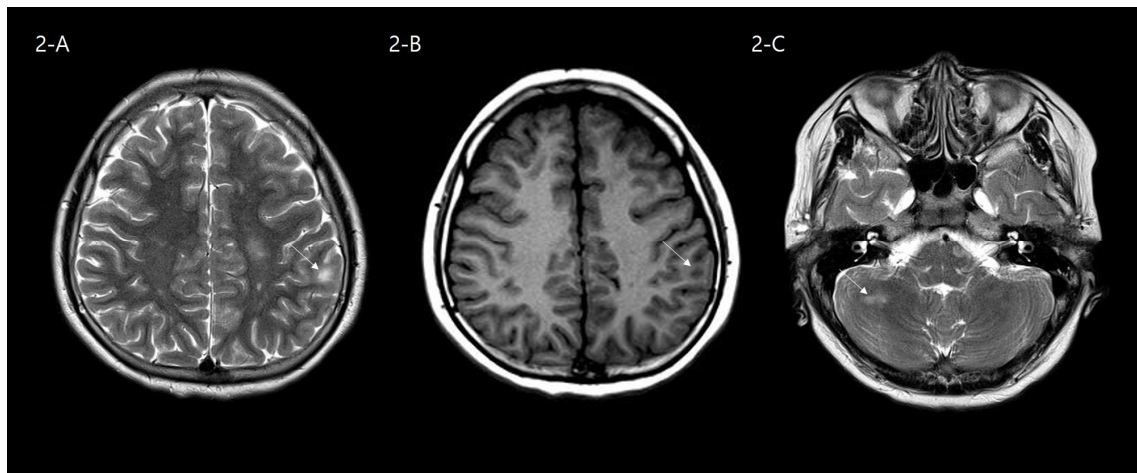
Brain MRI of patient 33 diagnosed with MS (oligoclonal bands in cerebrospinal fluid positive). Juxtacortical lesion with high signal intensity is shown on The T2 weighted image (A) and have low signal intensity on The T1 weighted images (B). Lesion in cerebellar white matter on The T2 weighted images (C). MRI, magnetic resonance imaging; MS, multiple sclerosis
